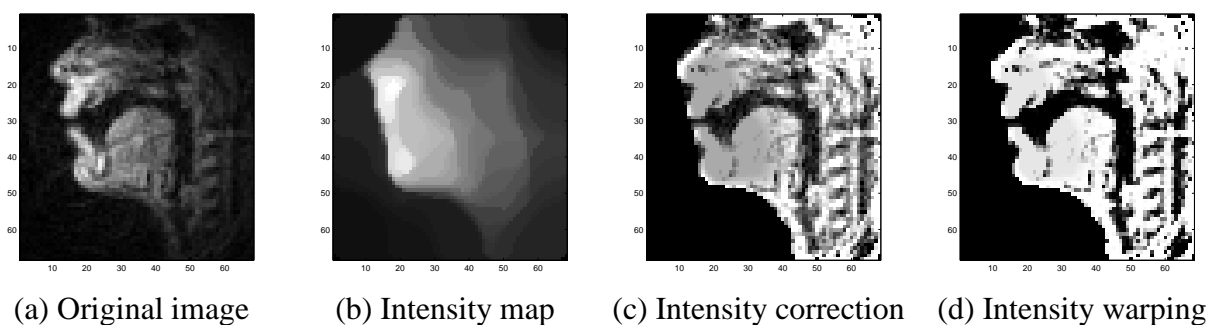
The MR image after each pre-processing.
